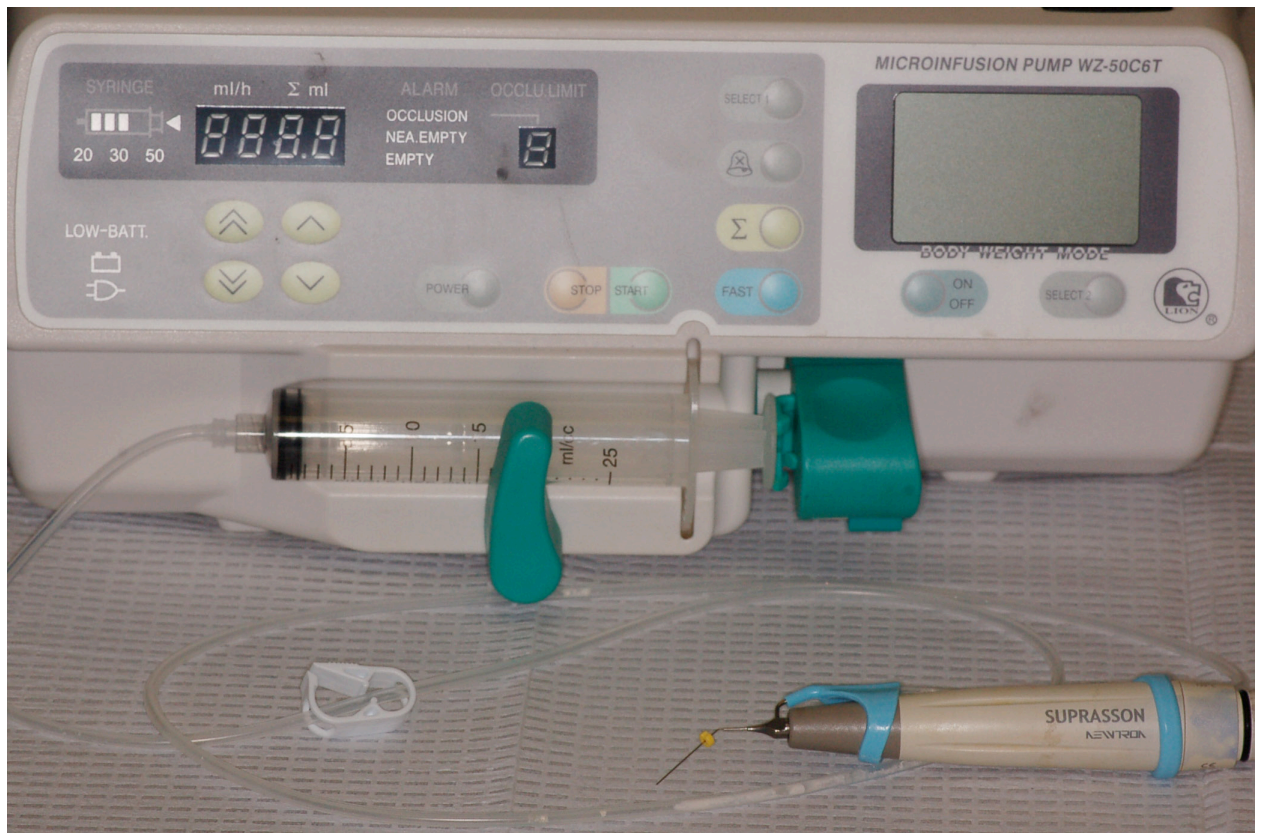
Pump for Ultrasonic Bypass System™.
